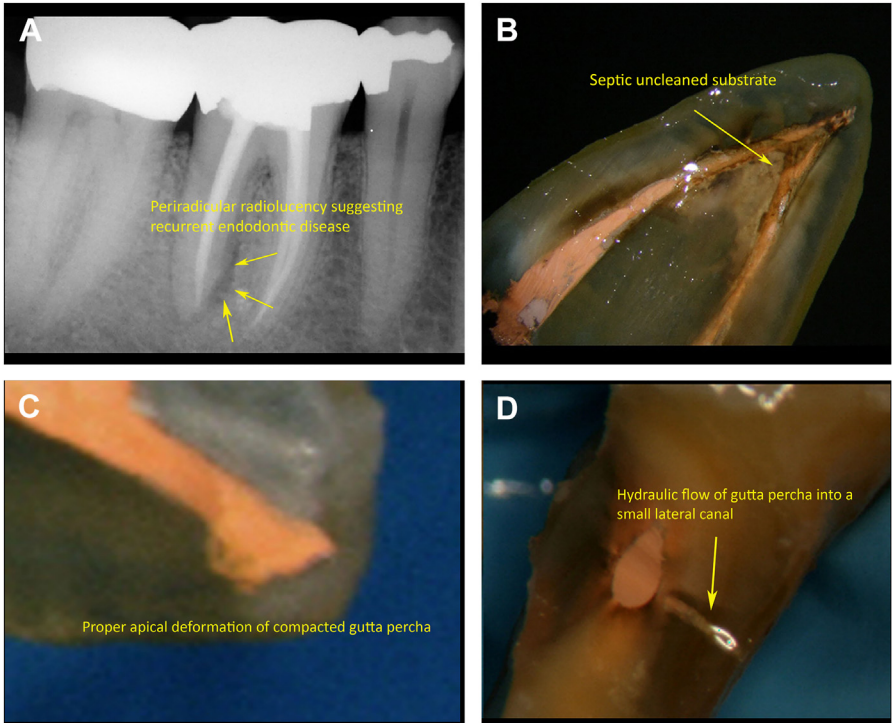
(A) Periapical radiograph suggesting an adequately treated first molar with failed RCT. (B) The mesial root apex of the extracted root canal-treated tooth showing poorly condensed gutta percha cones mixed with septic debris at the apex. (C) For reference, this is a different extracted root canal-treated tooth with properly condensed gutta percha and apical splaying. (D) The extracted tooth in (C) showing a hydraulic flow of filling material into the lateral canal with no voids.
